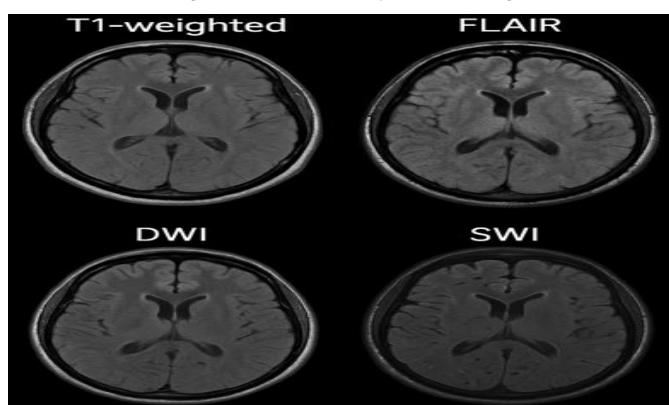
MRI Sequences in Hepatic Encephalopathy
